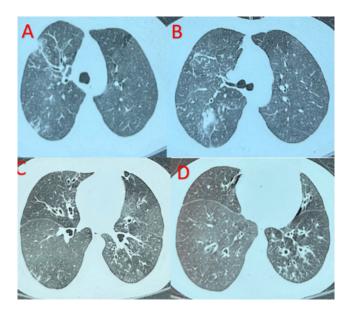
HRCT chest showing; A: Patches of consolidation with air bronchogram in lateral segment of right middle lobe; B: Patch of consolidation with air bronchogram in posterior segment of right upper lobe; C & D: Lower lobe bronchiectasis.
